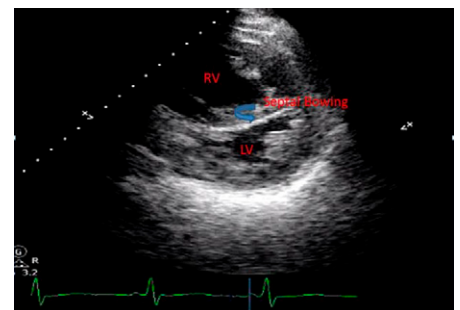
Short-axis view of two-dimensional echocardiogram showing evidence of right ventricular dysfunction with septal bowing toward the left. LV = left ventricle; RV = right ventricle.
